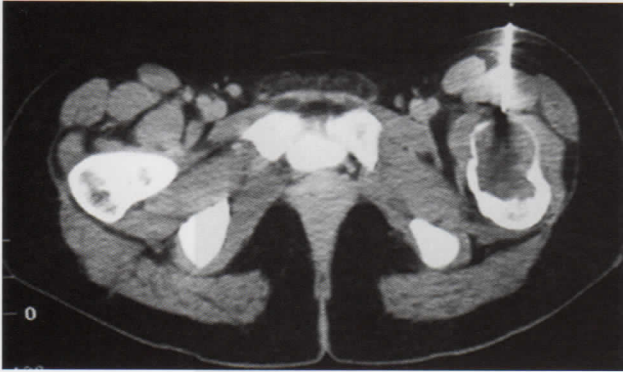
The CT-guided core needle biopsy of the primary lesion.
